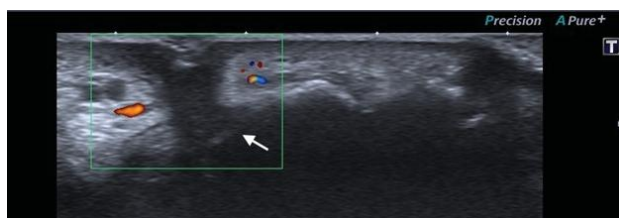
Longitudinal high-resolution ultrasound image with an 18 MHz linear transducer and color Doppler analysis, confirms the marked hypo echogenicity of the constricting band without flow on Doppler examination, observing the peripheral arterial vessels with flow inside (White arrow)
